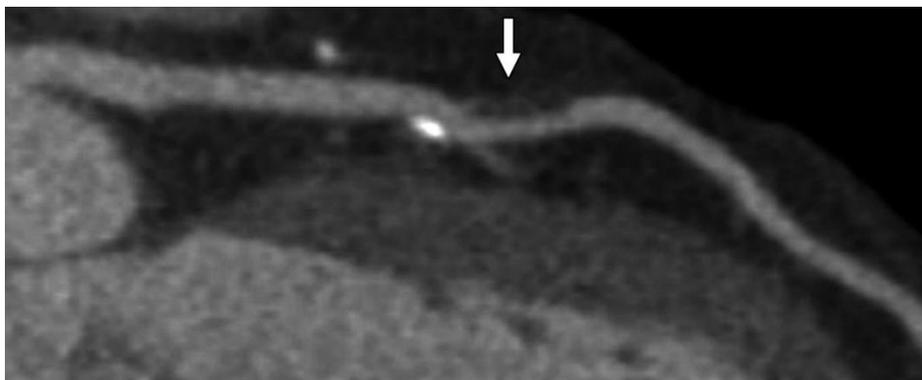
56-year-old woman who presented for coronary CT angiography because of a strong family history of heart disease. Curved reformatted image from coronary CT angiography shows a large soft plaque in mid left anterior descending artery (arrow). (19).
